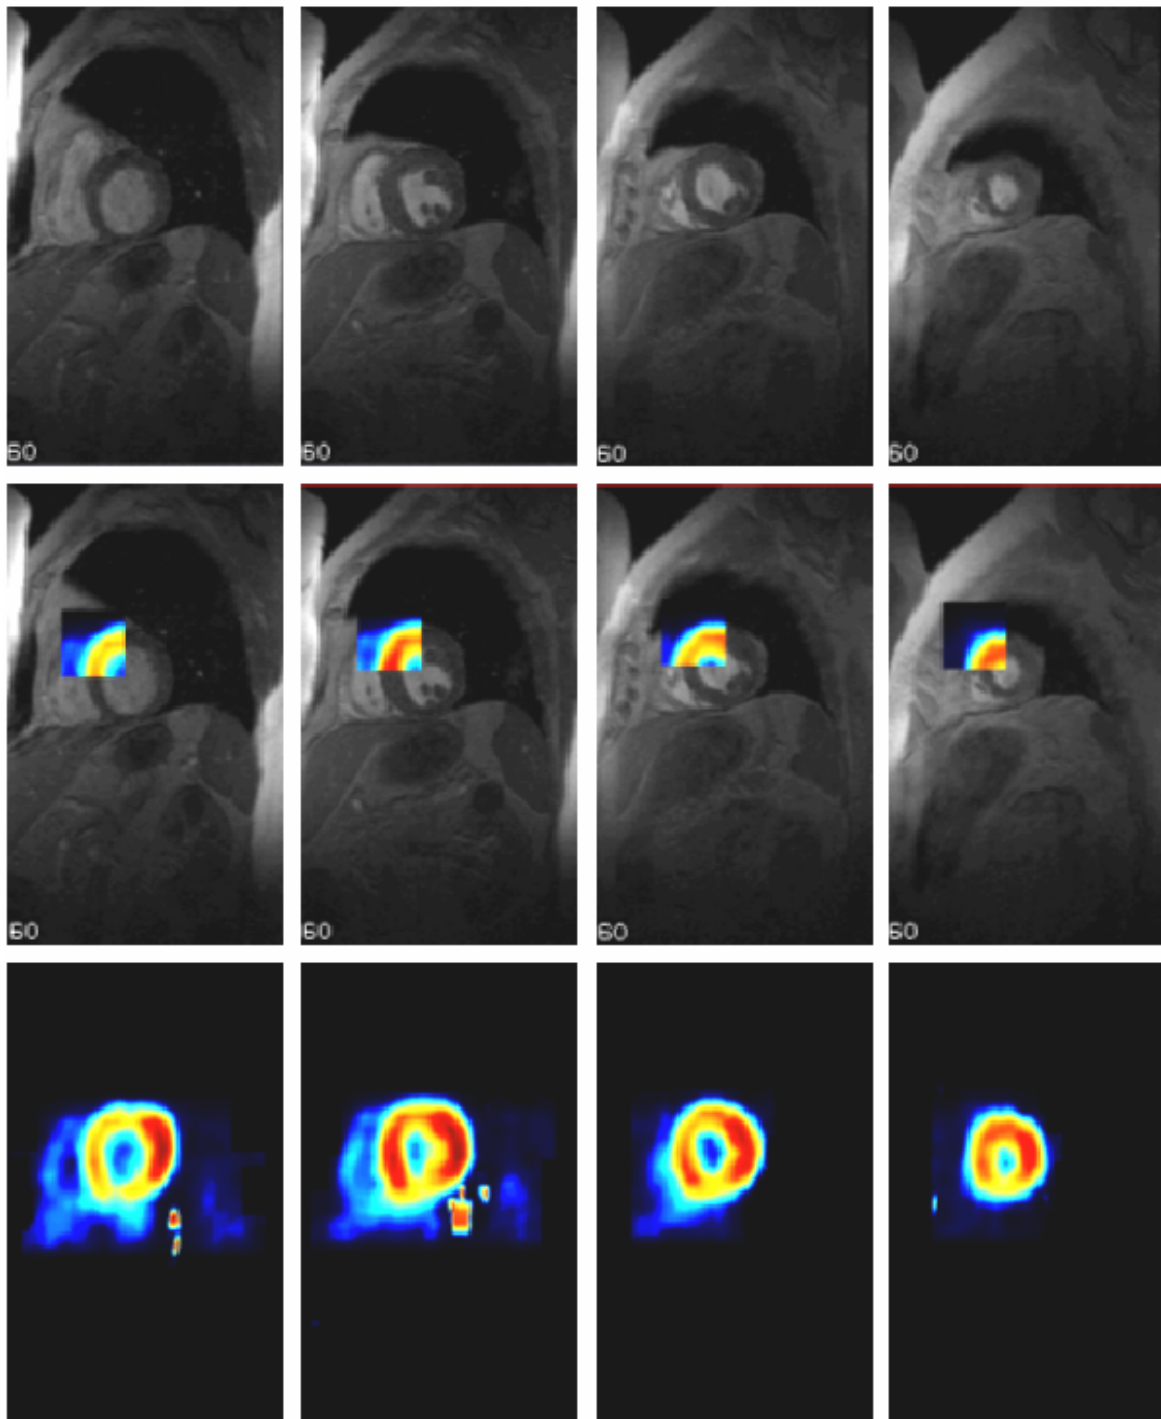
Coupes IRM-PA (haut) recalées à des images TEP 18F-FDG (bas) pour le cas E2 en télédiastole. La rangée centrale illustre le recouvrement des 2 modalités d'images pour une petite portion du myocarde ventriculaire gauche.
